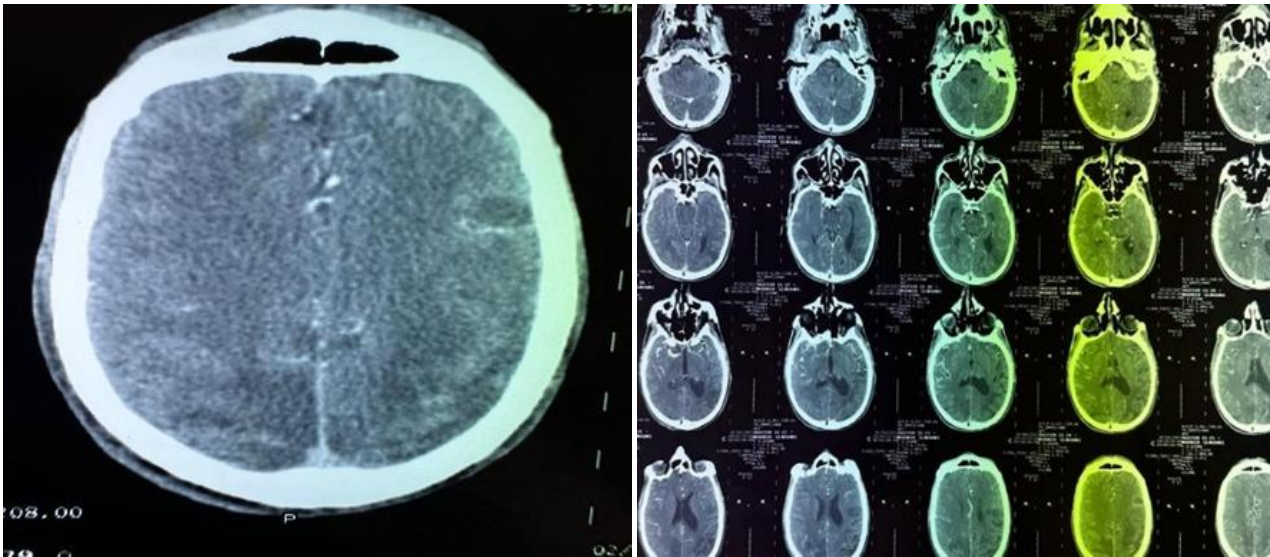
Cerebral CT: Spiral acquisition in millimeter slices with and without injection of contrast medium.
